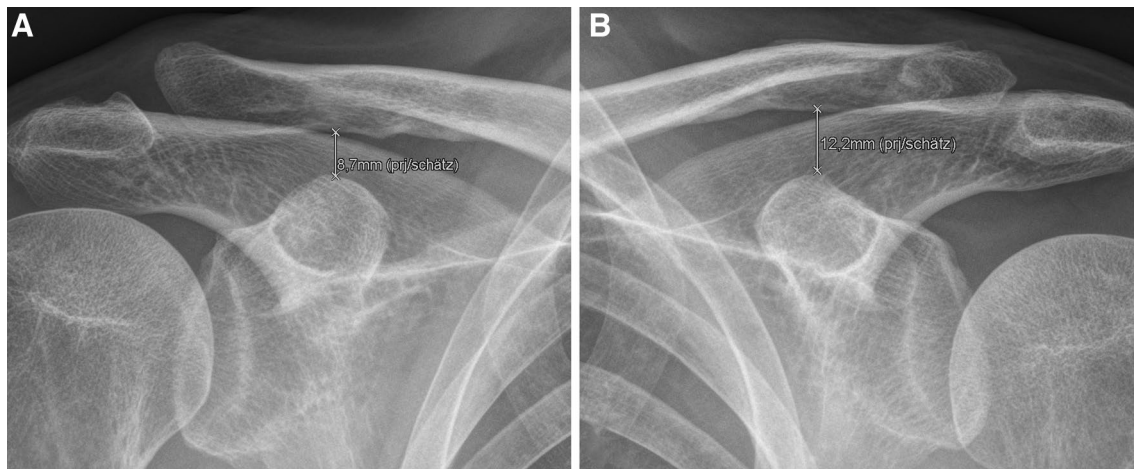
Dynamic assessment of coracoclavicular stability of a consolidated Neer IIB fracture following 3.5 mm LCP clavicular hook plate osteosynthesis (DepuySynthes) and implant removal. Follow-up bilateral anterior–posterior stress radiography with 10 kg vertical loading
